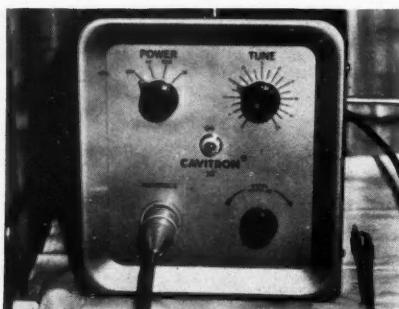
Ultrasonic unit; front view of cabinet.
